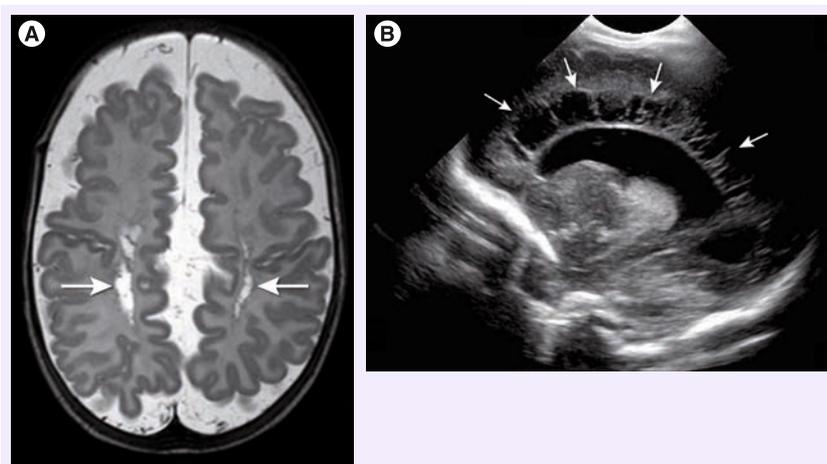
Focal white matter injury. (A) Cystic degeneration of white matter in the centrum semi-ovale (arrows) on axial T2-weighted magnetic resonance image. (B) Cystic periventricular leucomalacia readily diagnosed (arrows) on a sagittal ultrasonography image.
